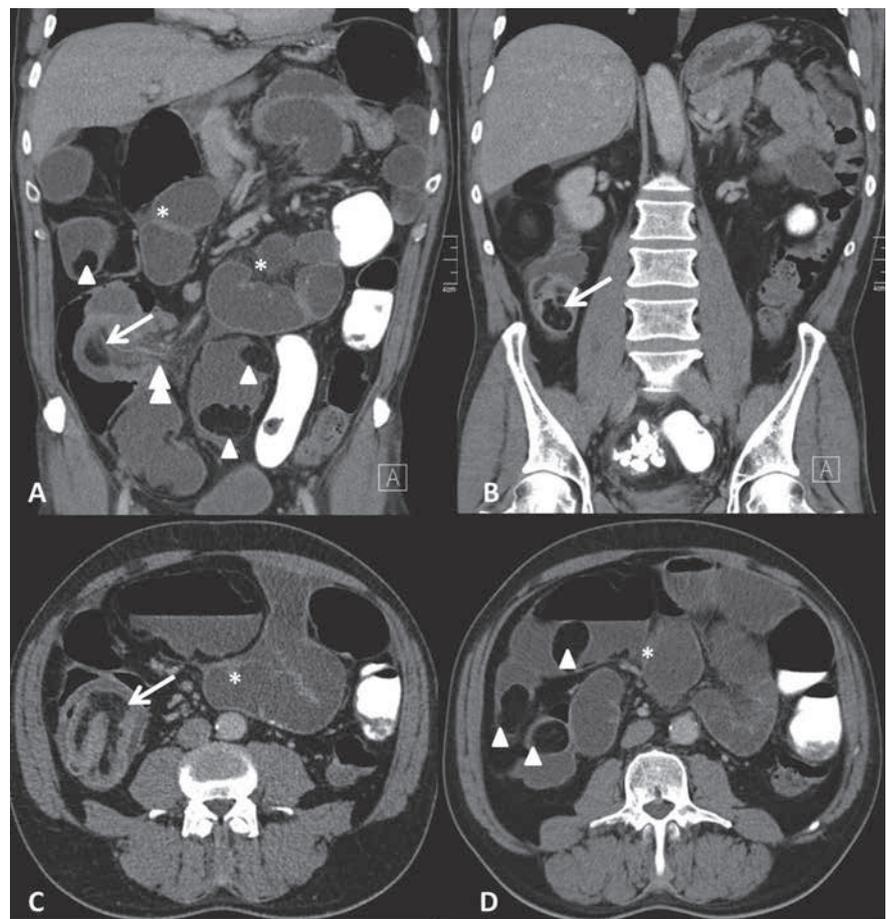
CT of the abdomen (A and B) coronal reformatted and (C and D) axial images show small bowel obstruction with dilated small bowel loops (asterisk) due to ileocolic intussusception (arrow in A and C) with infiltration of the mesenteric fat suggestive of ischemia (double arrowhead in A). A lead point could be identified (arrow in B). Also, multiple additional lipomas and diffuse submucosal fatty infiltration were seen throughout the terminal ileum (arrowheads).
